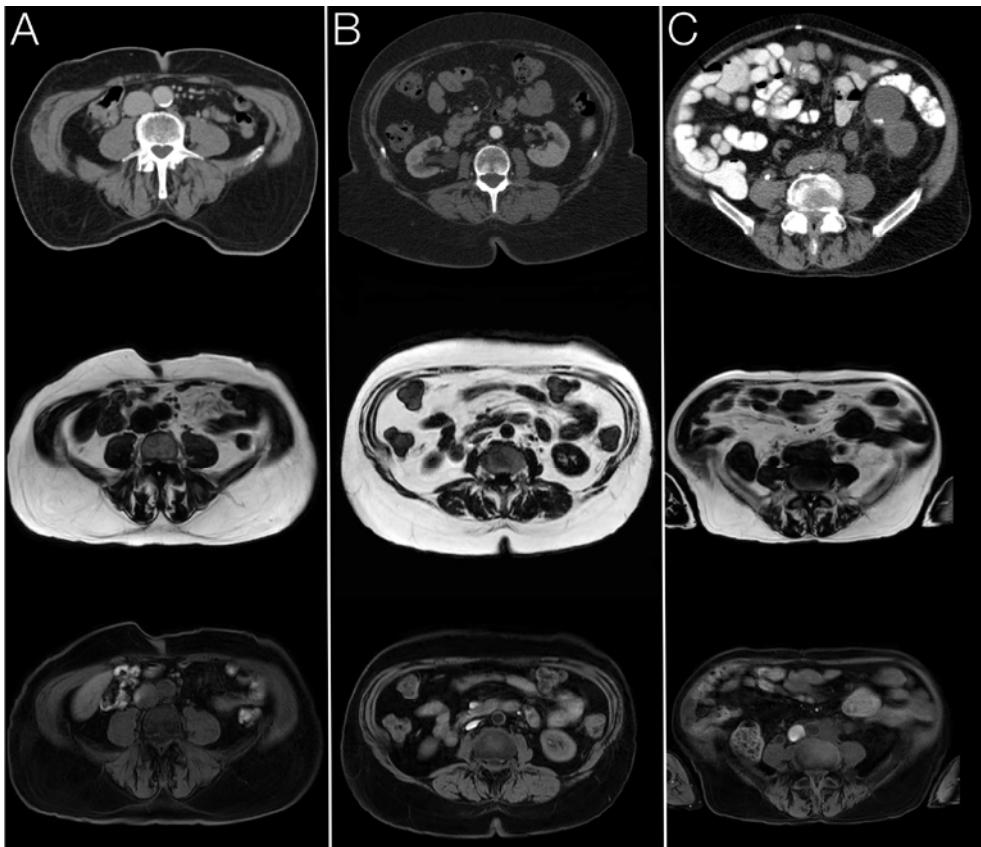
Both CT (top row) and MRI (middle and bottom rows) are highly reliable modalities to map the spatial distribution of abdominal adipose tissue.
